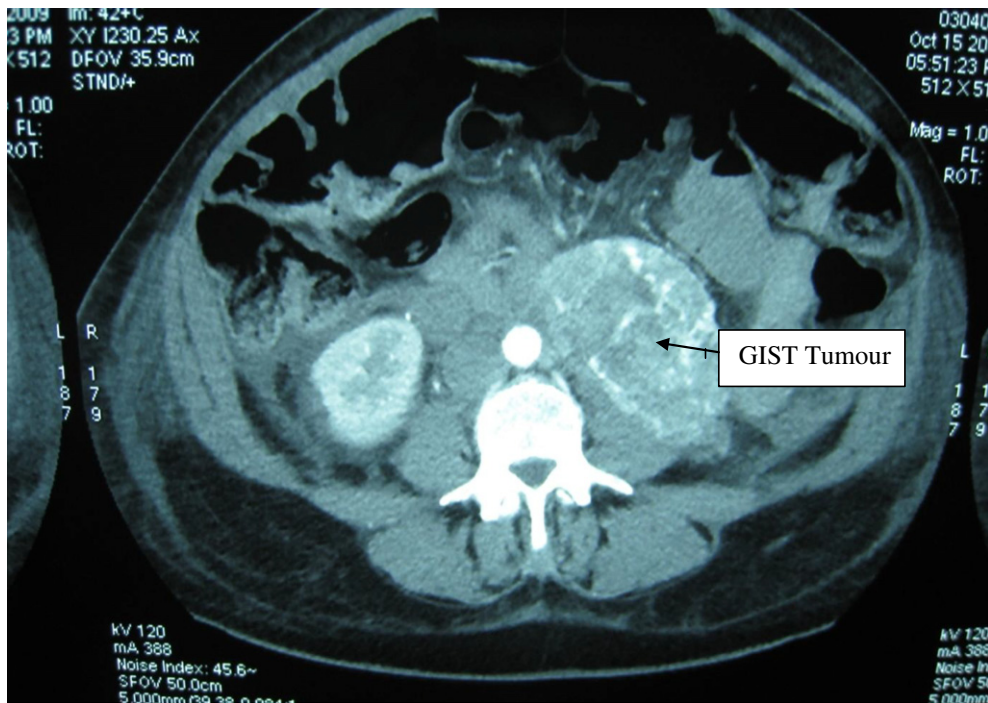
A CT scan showing the GIST tumour displacing the kidney, the psoas muscle and the 3rd part of the duodenum.
